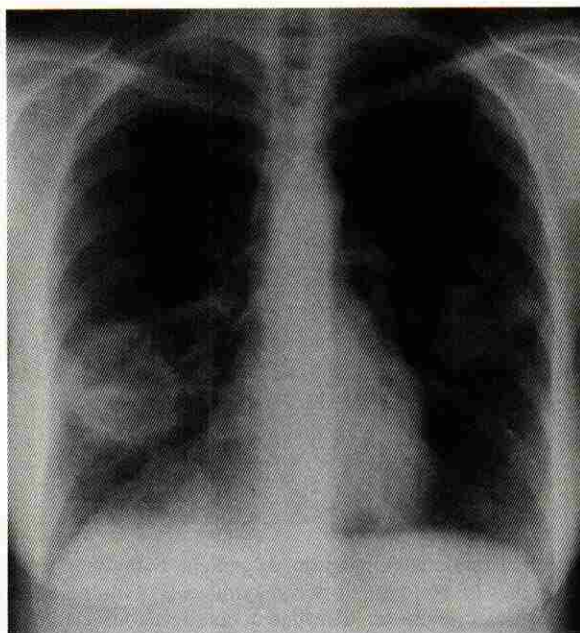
Posteroanterior chest radiograph of patient with Wegener granulomatosis. Note bilateral lung nodules and masses with cavitation. The walls of the cavitated masses are greater than 4 mm.
